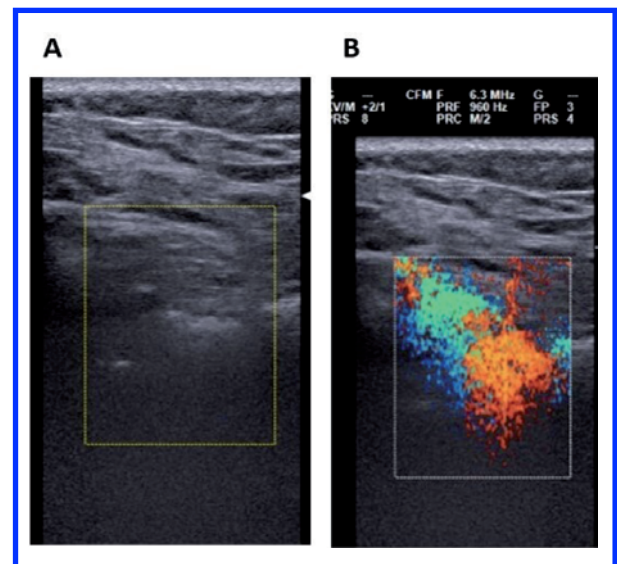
A) Ultrasound-guided infiltration of the sacroiliac joint: Failure to identify the needle. The arrow indicates the potential location of the needle tip. The identification box for the color signal, after the injection of a mixture of saline solution and 1% lidocaine, does not show the presence of the Jet Sign. Sacro (S) - Iliac (I) joint. B) Repetition of the injection of lidocaine + saline solution with greater pressure compared to the first injection. The identification box for the color signal clearly highlights the presence of the 'Jet Sign'.
